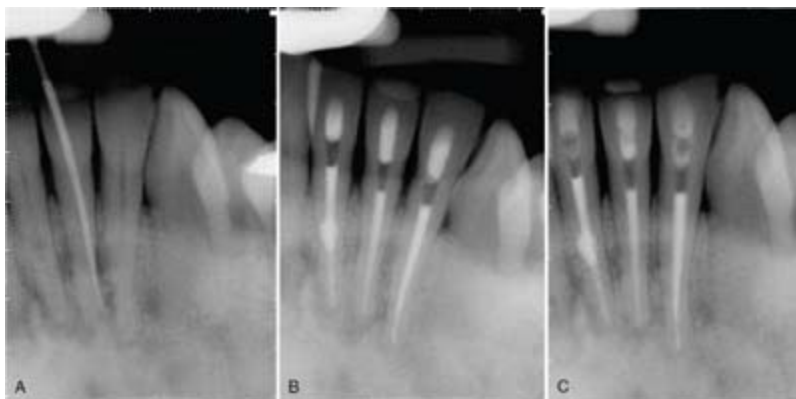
A, A 55-year-old female presented with pain, a sinus tract facial to #24, and a history of biopsy in the area several years prior. Teeth #23, #24, and #25 did not respond to cold or electric pulp testing. Radiographically the mixed radiolucent and radiopaque lesions were
